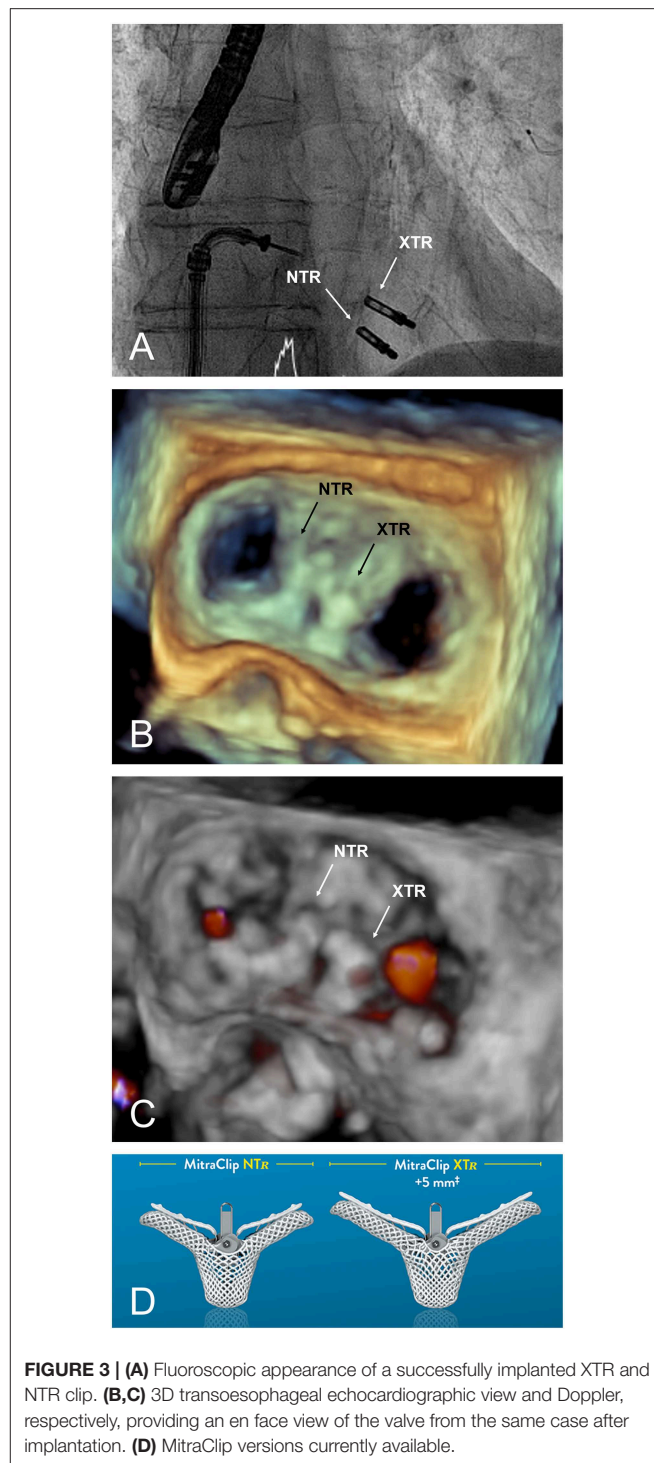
(A) Fluoroscopic appearance of a successfully implanted XTR and NTR clip. (B,C) 3D transoesophageal echocardiographic view and Doppler, respectively, providing an en face view of the valve from the same case after implantation. (D) MitraClip versions currently available.
